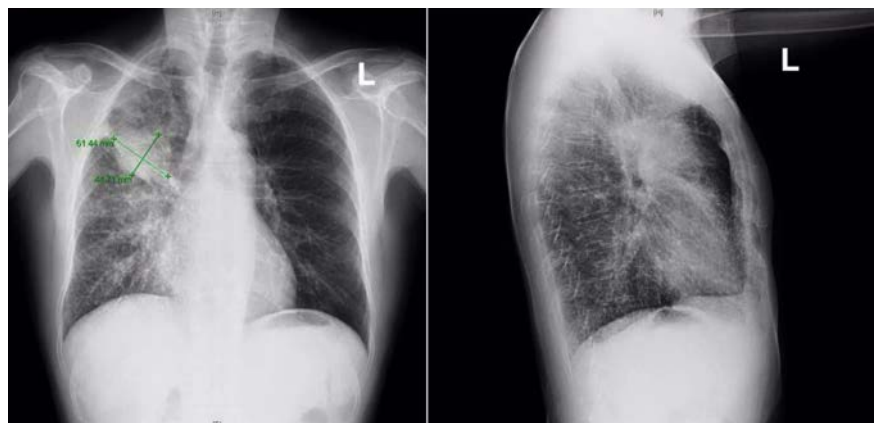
Initial chest X-ray (AP/Lat) showing right upper lobe lung mass diagnosed as non-small cell carcinoma of the lung.
